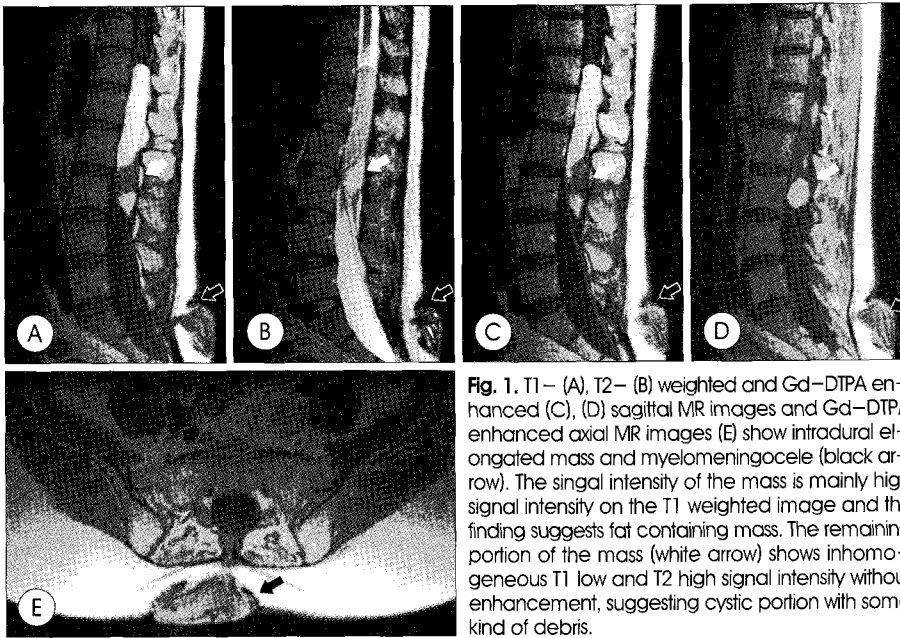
T1 – (A), T2 – (B) weighted and Gd–DTPA enhanced (C), (D) sagittal MR images and Gd–DTPA enhanced axial MR images (E) show intradural elongated mass and myelomeningocele (black arrow). The signal intensity of the mass is mainly high signal intensity on the T1 weighted image and this finding suggests fat containing mass. The remaining portion of the mass (white arrow) shows inhomogeneous T1 low and T2 high signal intensity without enhancement, suggesting cystic portion with some kind of debris.
